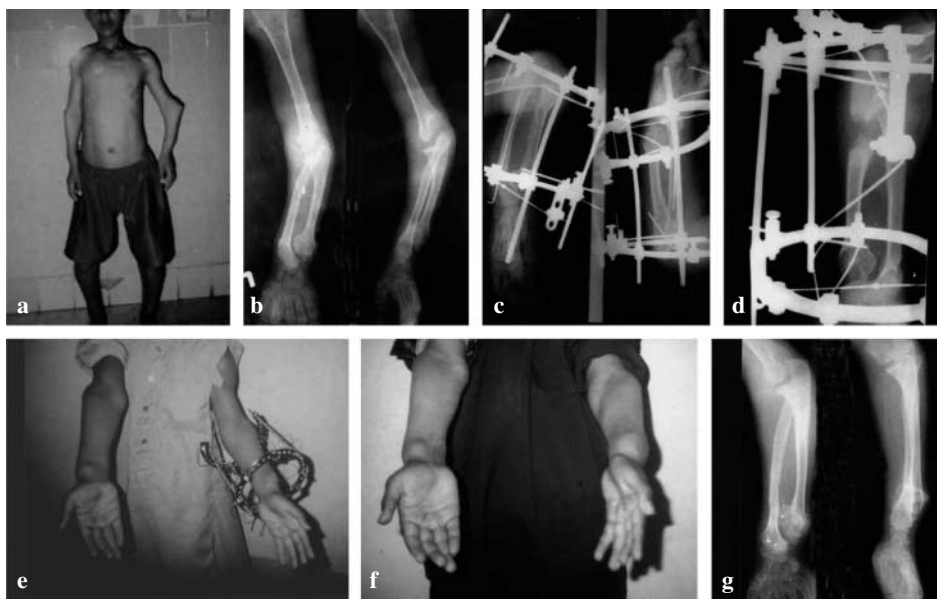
A 13.5-year-old boy (case 2) with hereditary multiple exostosis with dislocated radial head at the left elbow. a Preoperative photograph. b Preoperative anteroposterior and lateral radiographs. c Immediate postoperative radiograph revealing osteotomy of the upper ulna and distal radius with K-wire fixation. d Radiograph at the end of distraction. e Photograph at the end of correction. f Photograph after removal of the apparatus. g Radiograph after removal
